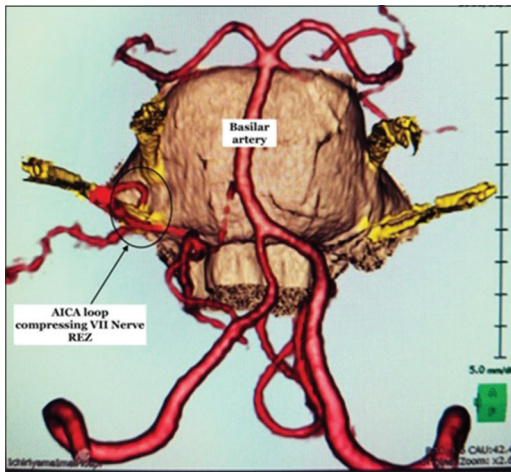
Fusion image (magnetic resonance imaging brain SPGR sequence and computed tomography angiography) demonstrating anterior inferior cerebellar artery (AICA) loop compressing right side VII cranial nerve root entry zone
